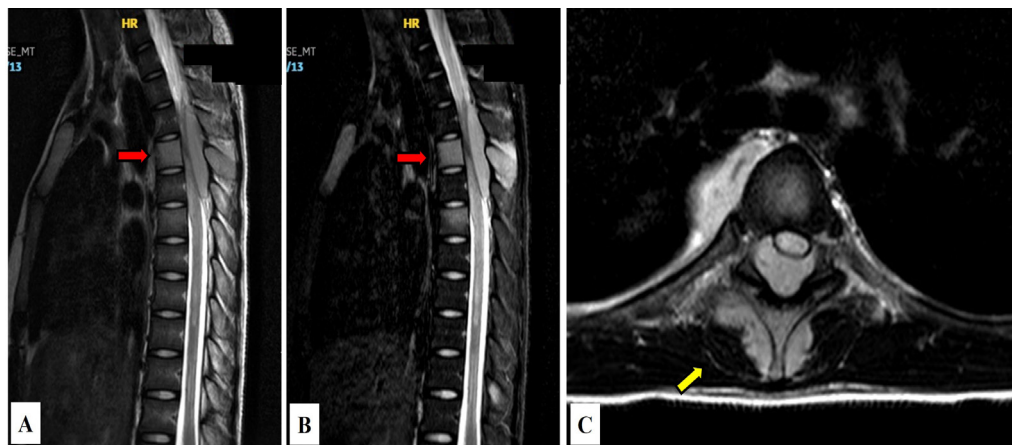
Case 2. MR images of the thoracic spine: (A) Sagittal T1-weighted (T1WI); (B) sagittal STIR sequence; and (C) axial T2-weighted at the T4 vertebral level. T4 was marked with a red arrow in images (A) and (B). A well-defined, lobulated right paravertebral soft tissue lesion at the T2–T5 vertebral levels was highlighted with a yellow arrow in image (C). The lesion appeared iso-hyperintense to muscle on T1WI (A), hyperintense on T2WI (C), not suppressed on FLAIR and STIR sequences (B), and demonstrated heterogeneous enhancement on post-contrast imaging. The lesion extended posteriorly, invaded the erector spinae muscles bilaterally and compressed the posterior thecal sac through the spinal canal.
